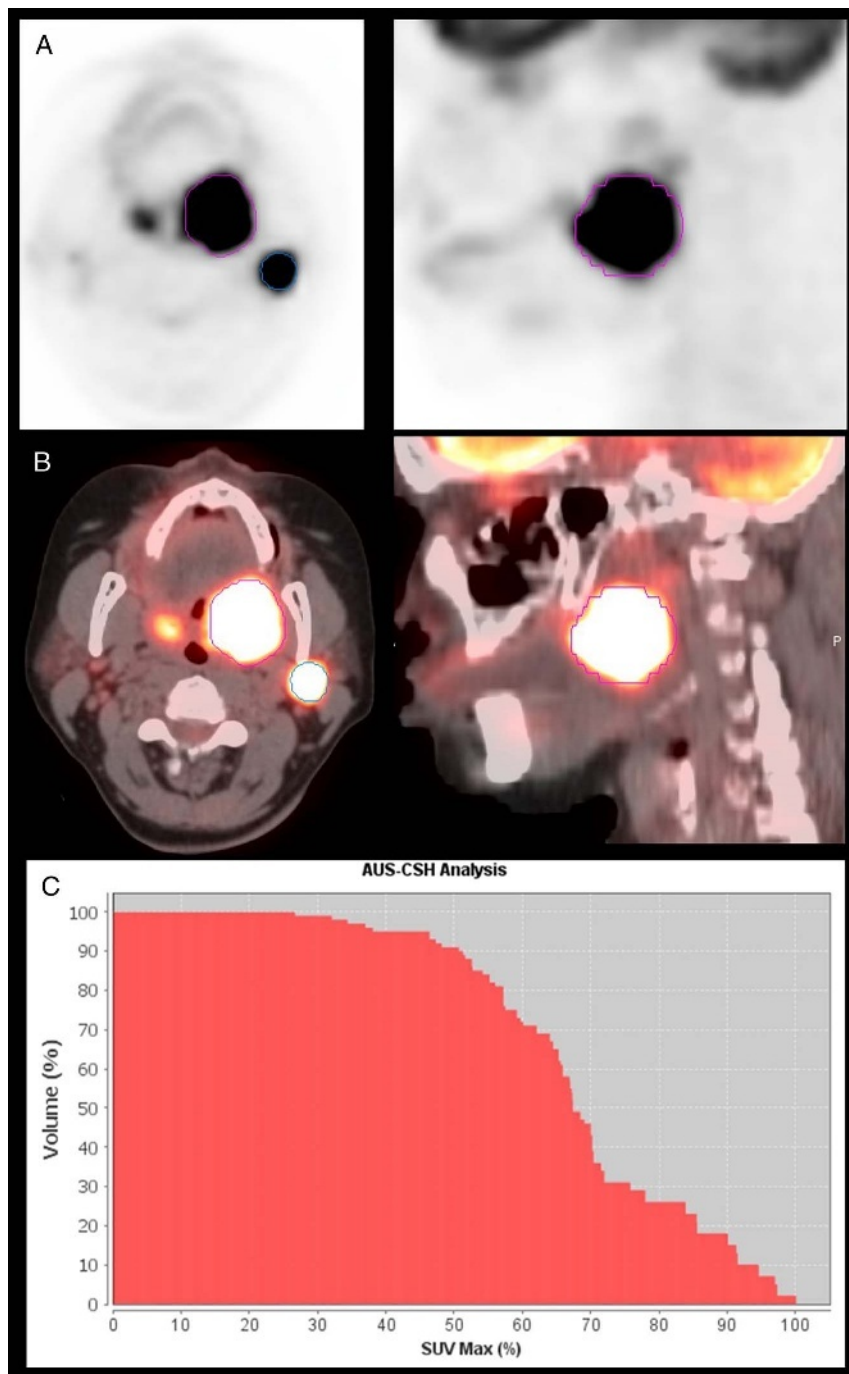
A 53-year-old man with HPV-positive tonsil SCC, stage IVa (T2 N2b M0). Axial and sagittal PET (A), axial and sagittal fused PET/CT (B), and axial and sagittal fused PET/CT images demonstrate intense FDG-avid primary tumor and left level II node, with the highest SUV_{max} of 16.4, MTV_{Total} of 21.7 mL, and TLG_{Total} of 221.7 g, by gradient segmentation. The calculated AUC-CSH index was 0.68 (C). Patient underwent chemoradiation therapy, being free of disease 5 years postdiagnosis.
